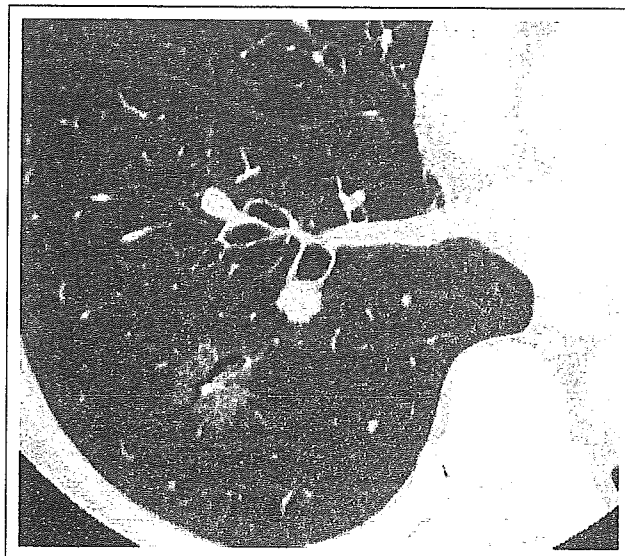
Ground glass density or nonsolid nodule. Chest computed tomography image focused on the right lower lobe shows a 1.5-cm ground-glass density or nonsolid nodule.
